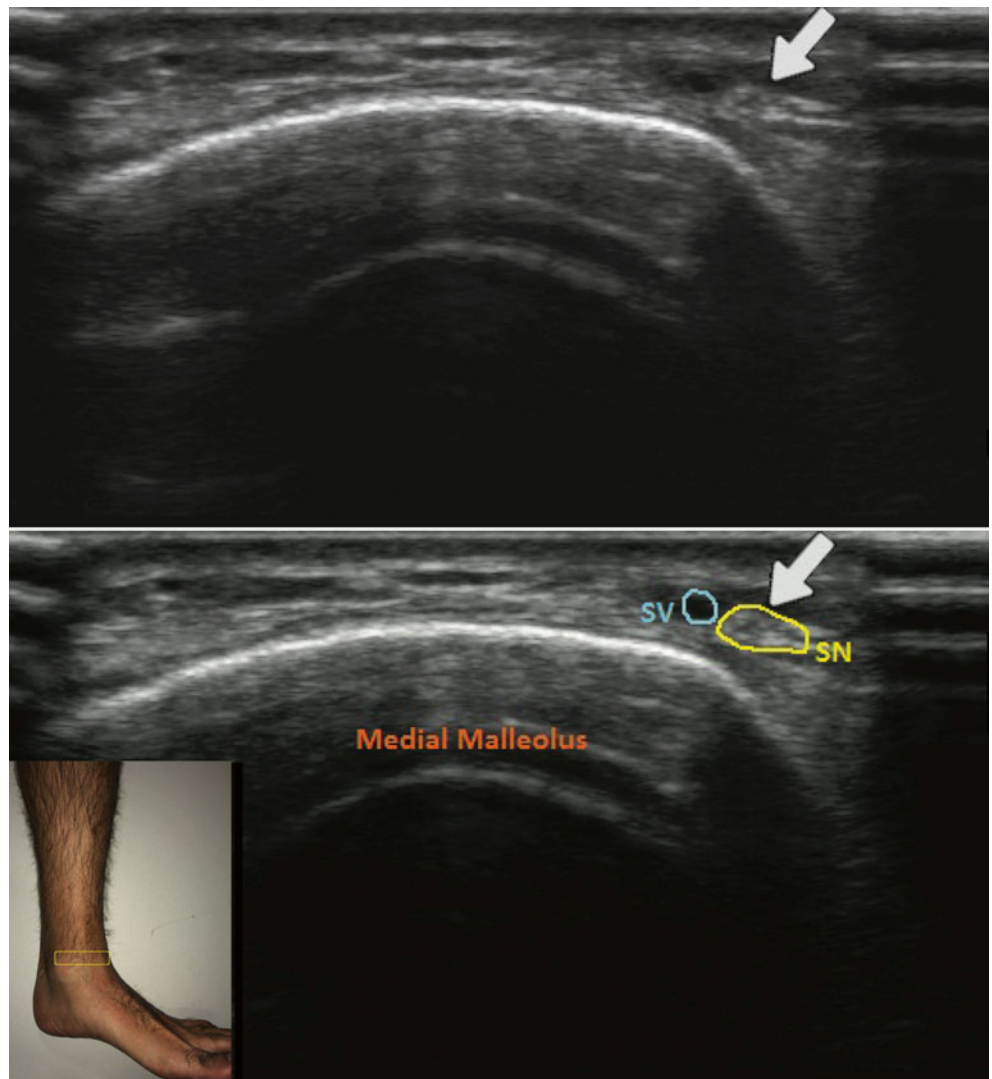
In-plane ultrasound injection of the distal saphenous nerve. Note the tourniquet to increase the size of the saphenous vein for easier localization (Image courtesy of Michael Brown, MD)
